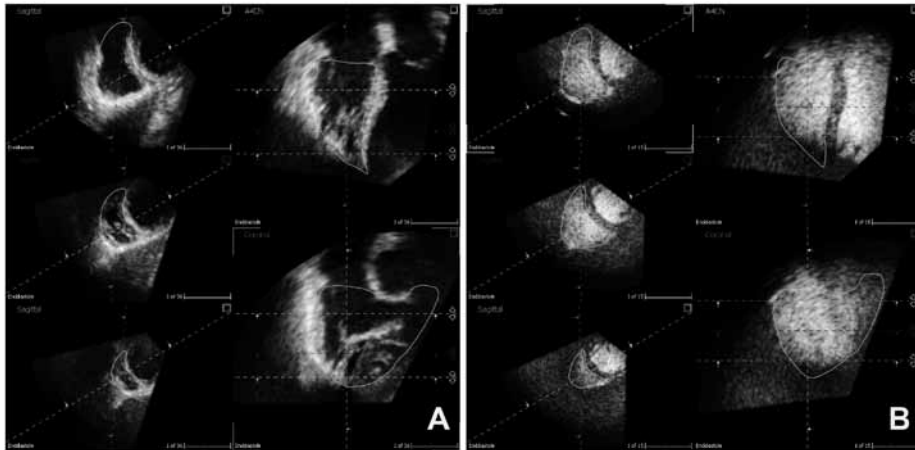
Example of a fair-quality echocardiogram by non contrast-enhanced RT3DE (A), and contrast-enhanced RT3DE (B) in a 38 years-old female. Display from the four-dimensional RV function analysis program showing the final stage of contour detection in which manual correction of the contours can be applied in any cross-section or phase of the cardiac cycle.
